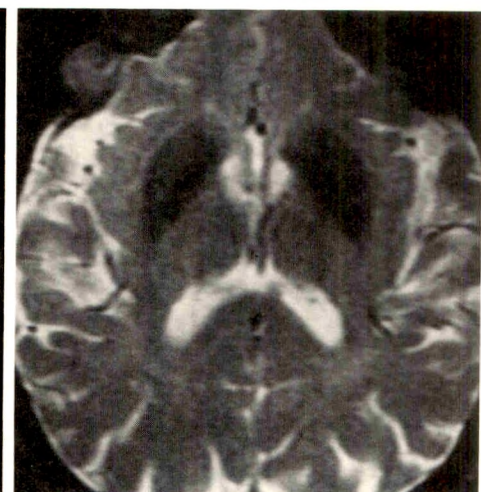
MR image (2500/80) of 68-year-old man with Parkinson disease. Hypointensity involves entire putamina diffusely. They were graded 3.
